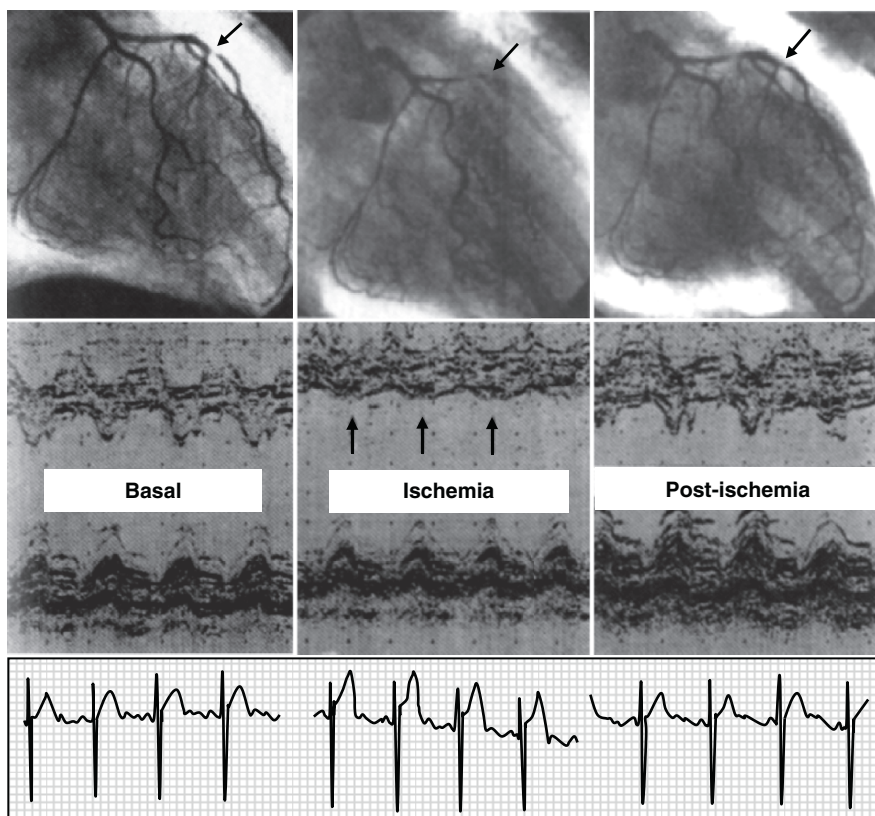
Coronary angiographic (*upper panels*) and echocardiographic monodimensional tracings (*lower panels*) during attacks of variant angina induced by ergonovine maleate. At baseline, left anterior descending coronary artery shows a tight stenosis (*left panel*); the artery is totally occluded by a complete vasospasm during ischemia (*middle panel*); and it is again open in the recovery phase (*right panel*). The corresponding three frames of an original M-mode recording document a fully reversible sequence of myocardial ischemia. The septum moves normally at rest (*left panel*) and is obviously akinetic during ischemia (*middle panel*). During the recovery phase (*right panel*), the previously ischemic wall exhibits a significant overshoot in motion and systolic thickening. (From [15])
